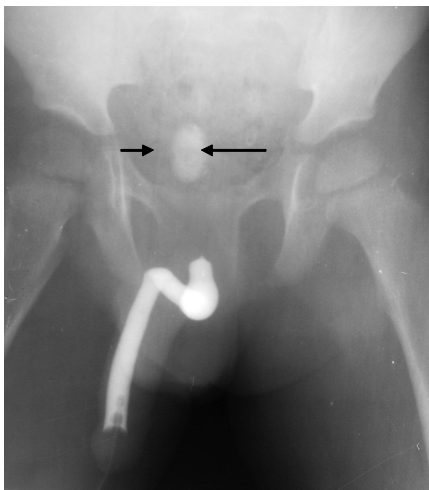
Radiograph showing retrograde urethrograph done before bladder catheterization of the patient. Note the abrupt termination of contrast column with rounding at about the level of prostatic urethra in a 'virgin urethra'; a rarely reported finding in posterior urethral valve. The calcified bladder stone is arrowed.
